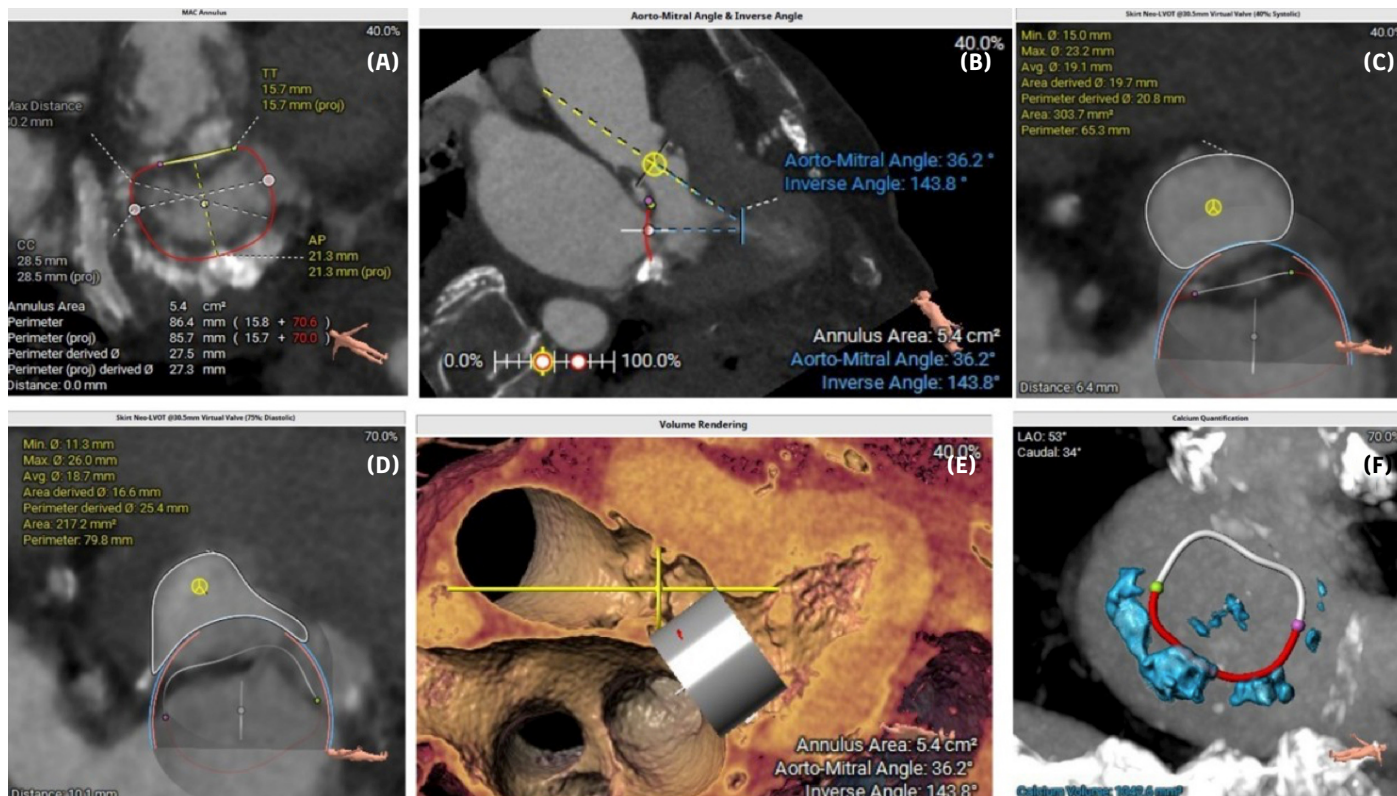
(A) Gated computed tomography (G-CT) image showing heavy and circumferential mitral annular calcification (MAC). (B) G-CT image showing an acute aorto-mitral angle (AMA). (C) G-CT image showing the predicted skirt neo-left ventricular outflow tract (LVOT) area using a virtual 30.5 mm Myval valve: 303.7 mm² (40% systole). (D) G-CT image showing the predicted skirt neo-LVOT area using a virtual 30.5 mm Myval valve: 217.7 mm² (75% diastole). (E) G-CT image showing an acute AMA using a virtual 30.5 mm Myval. (F) G-CT image showing calcium quantification of MAC.
